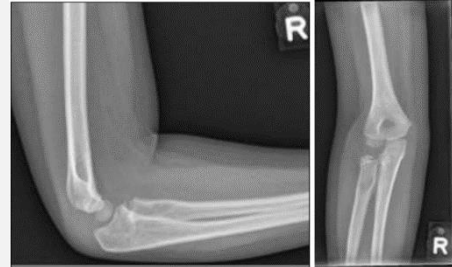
Post-operative lateral and AP radiographs showing an enlocated radial head
